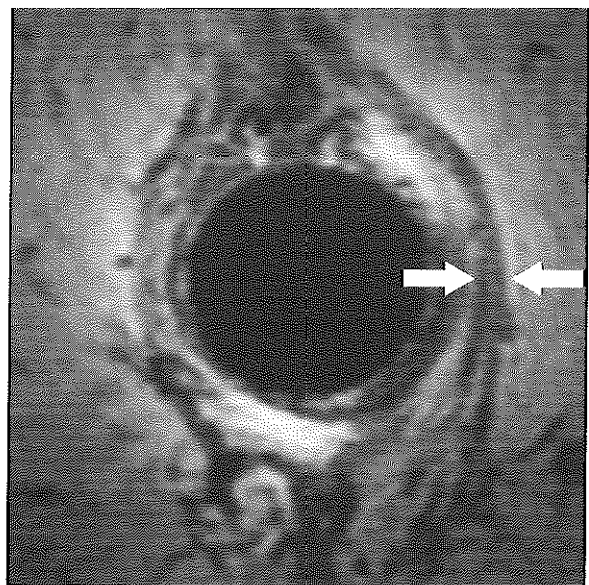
Atrophy of the external anal sphincter on endoanal MRI with anterior defect. *Arrows* relatively dark gray external anal sphincter
